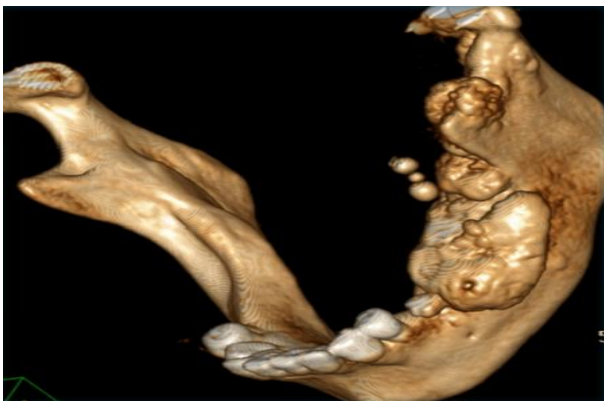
CT scan revealing proliferative changes as well as perforation of the buccal cortex.
